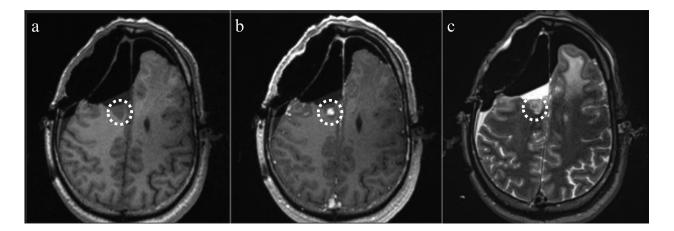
A newly enhanced lesion on iMRI at second surgery. (A, B) Comparison of noncontrast TIWI, showing a low intensity lesion in the area enclosed by dotted circle, with contrast-enhanced T1WI reveals homogeneous enhancement which is distinct from the resected cavity. Preoperative MRI (see Fig. 2C) showed no enhanced lesion in the same area. (C) T2WI, showing mixed low and high intensity.
